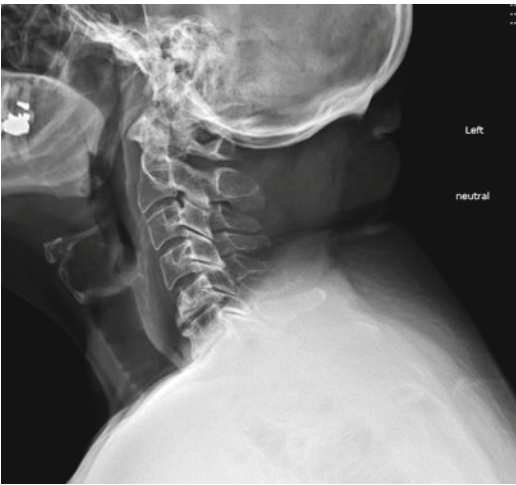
Sagittal plain radiograph demonstrating multilevel cervical spondylosis, most advanced at C5–C6 and C6–C7, with grade I retrolisthesis of C5 on C6
